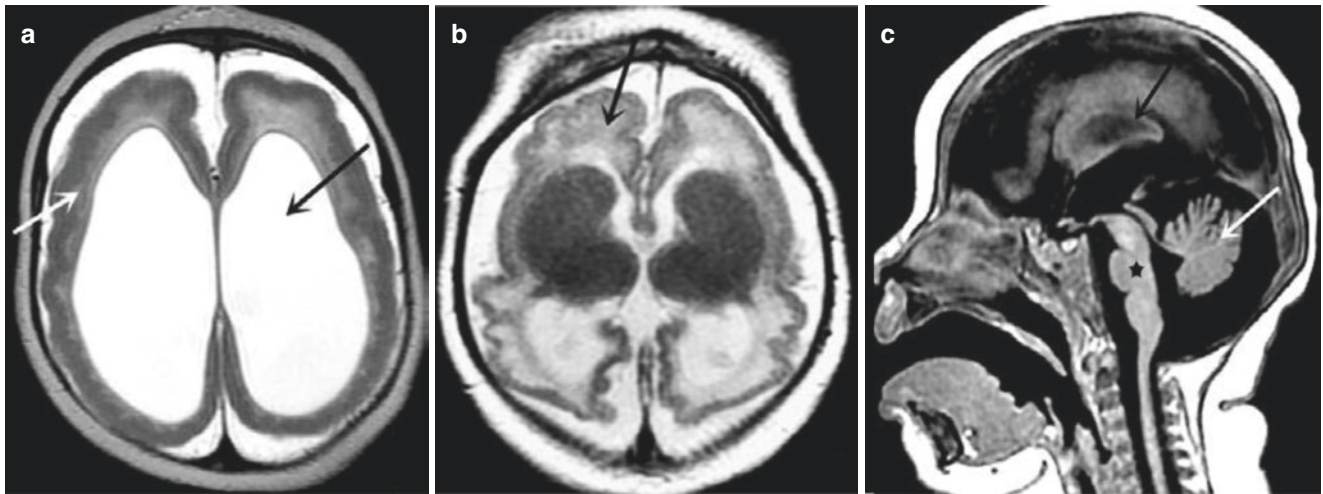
(a) Axial T2-weighted MR image shows a thickened cortex (white arrow) and ventriculomegaly (black arrow). (b) Axial T2-weighted MR image shows cortical malformations (black arrow). (c) Sagittal T1-weighted MR image shows cerebellar atrophy (white
